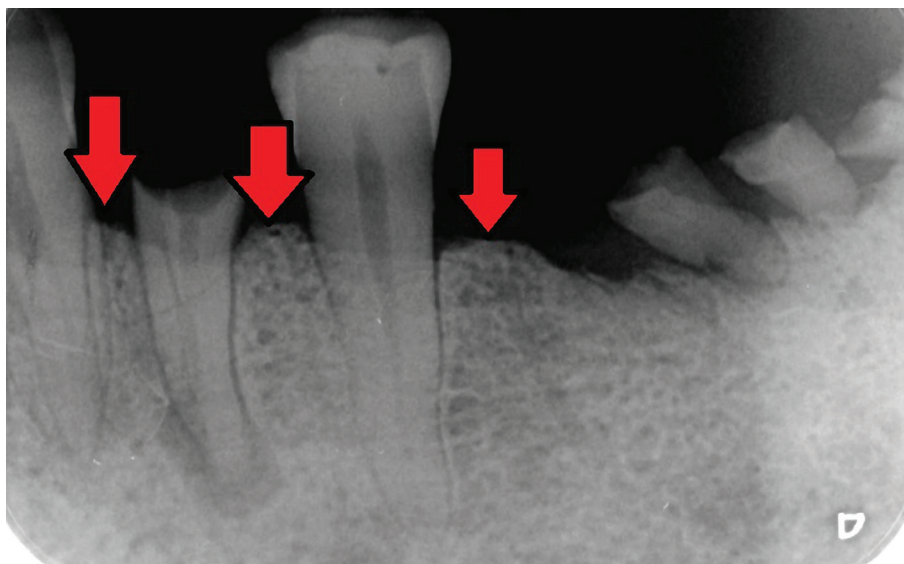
Dental x-ray of a patient with DM and CKD. Bone resorptions are marked with arrows.
